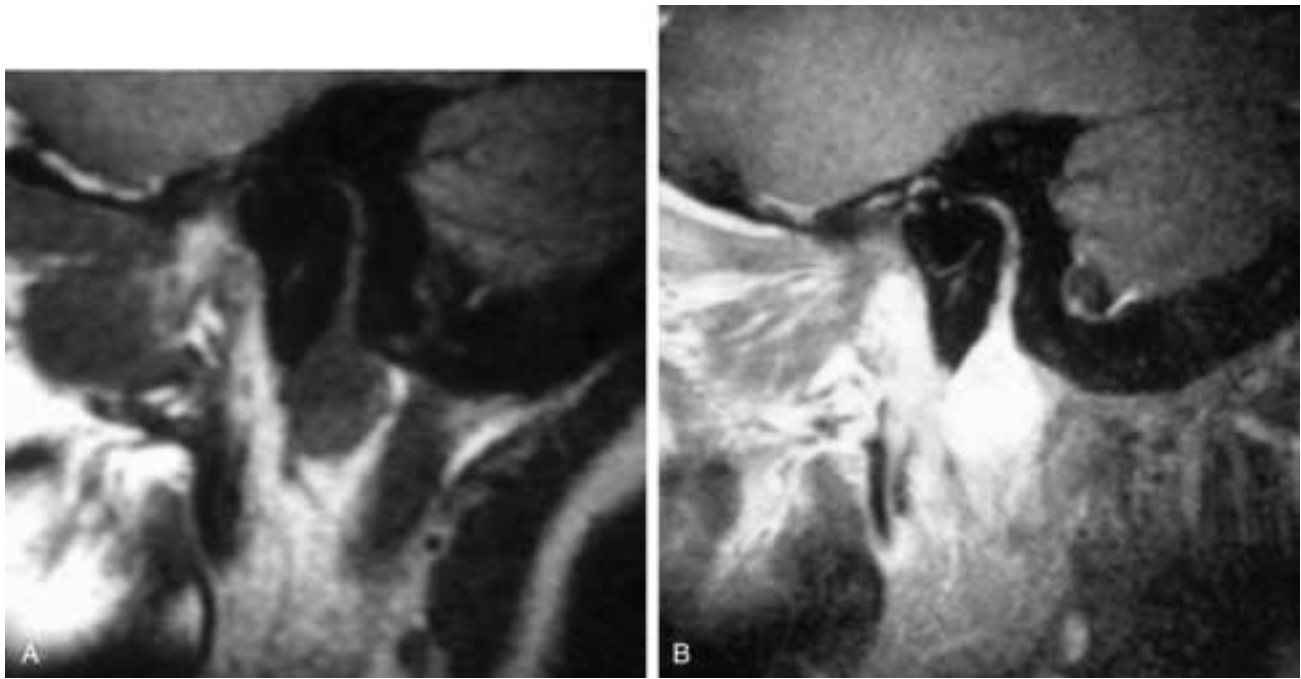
Sagittal T1-weighted (A) and T1-weighted, fat-suppressed, contrast-enhanced (B) MR images show a well-defined mass in the left parotid gland with widening and enhancement of the facial nerve up into the midmastoid portion of the nerve canal. This patient had an AdCC with retrograde tumor spread.
